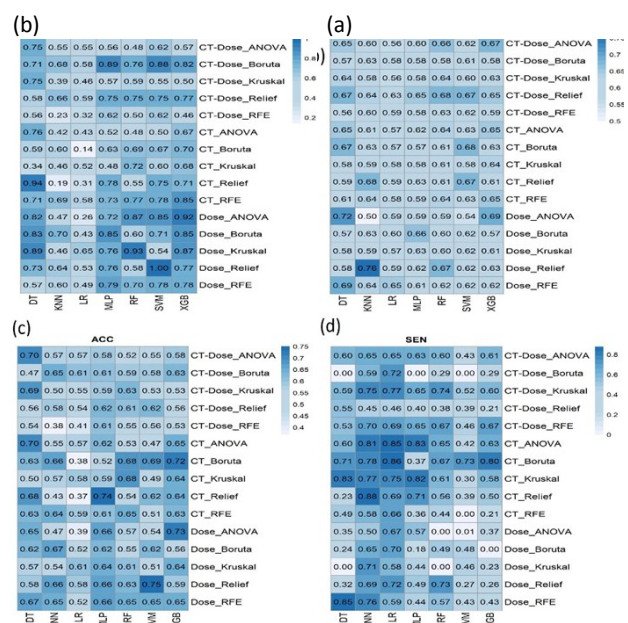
Performance comparison of various feature selection methods (ANOVA, Boruta, MRMR, RFE) and machine learning algorithms (KNN, LR, MLP, RF, XGB) on predicting bladder toxicity using CT, Dose, and CT-Dose datasets. The performance metrics - (a) SPE, (b) AUC, (c) ACC, and SEN (d) - for each combination of feature selection and classification algorithm on the test dataset.
